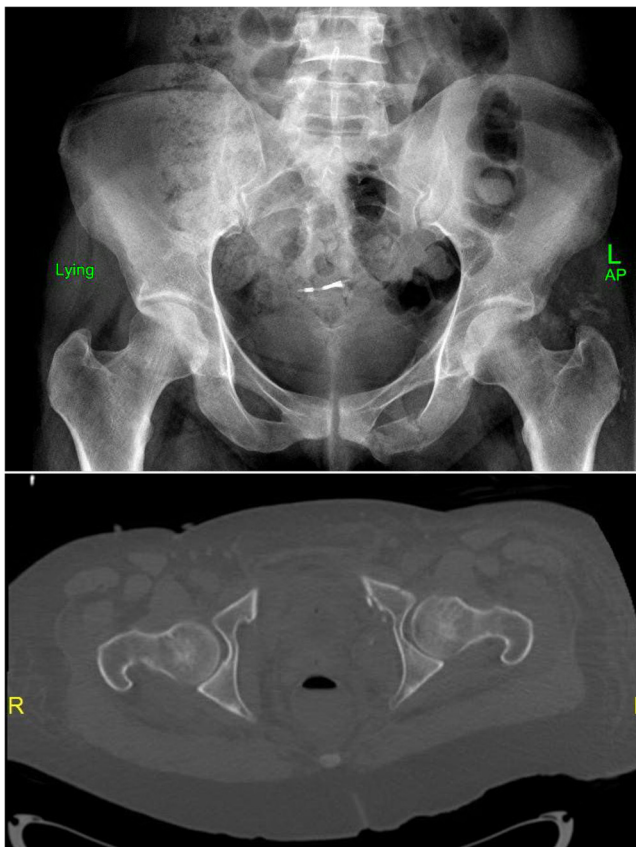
post-reduction AP radiograph and axial CT scan Cut.
